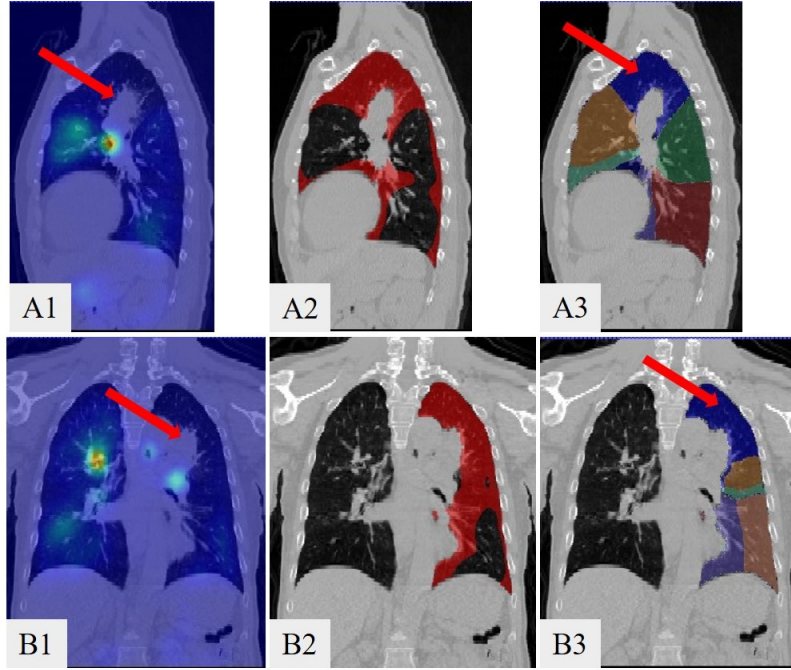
The sagittal and coronal views of an example of the tumor blocked the L1 segment and the comparison between the blocked corresponding bronchopulmonary segments and the low functional region. The red arrows in Figures (A1) and (B1) indicate the tumor's location. Figure (A1) is the sagittal view of the overlap of the CT image with the ventilation image. Figure (A2) shows the sagittal view of the low functional regions (red mask) on the CT image. Figure (A3) shows the sagittal view of the bronchopulmonary segments in the CT image, and the blocked segment is shown in blue. The red arrows in Figures (A3) and (B3) indicate the blocked segment. Figures (B1) – (B3) are the corresponding images in the coronal view.
